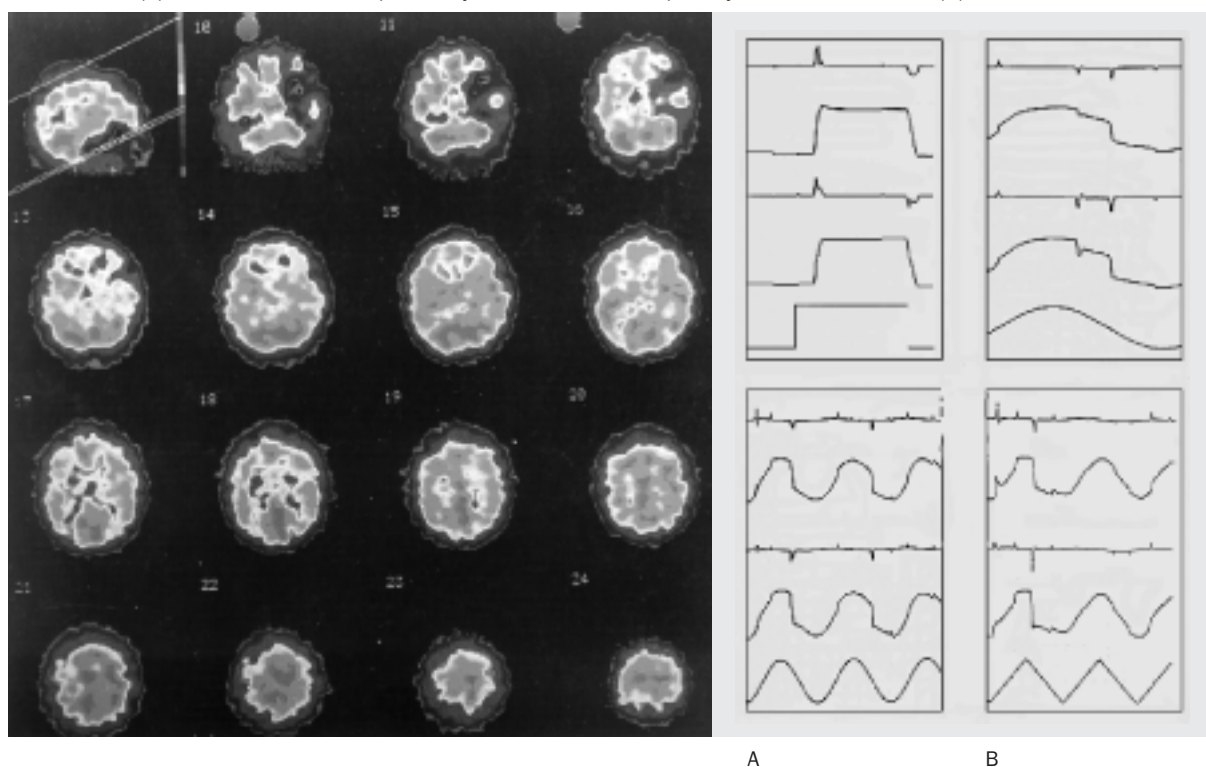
On the left of figure 2 the SPECT of a patient with SLE being suspected for CNS involvement is shown. The left frontal and parietal cortex are hypoperfused. The patient's eye movement recordings are shown on the right. The saccadic movement is unaffected (A), however, the smooth pursuit eye movement is disrupted by corrective saccades (B).
